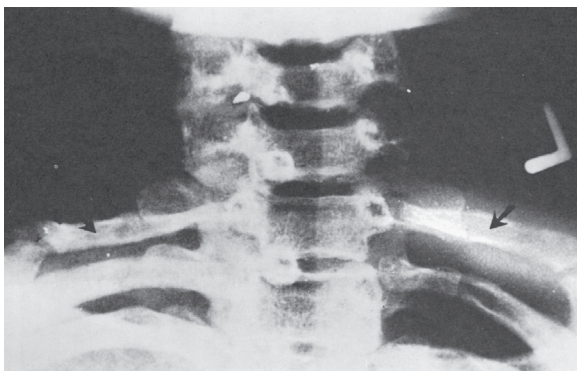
■ Radiographic film showing bilateral cervical ribs (arrows).
